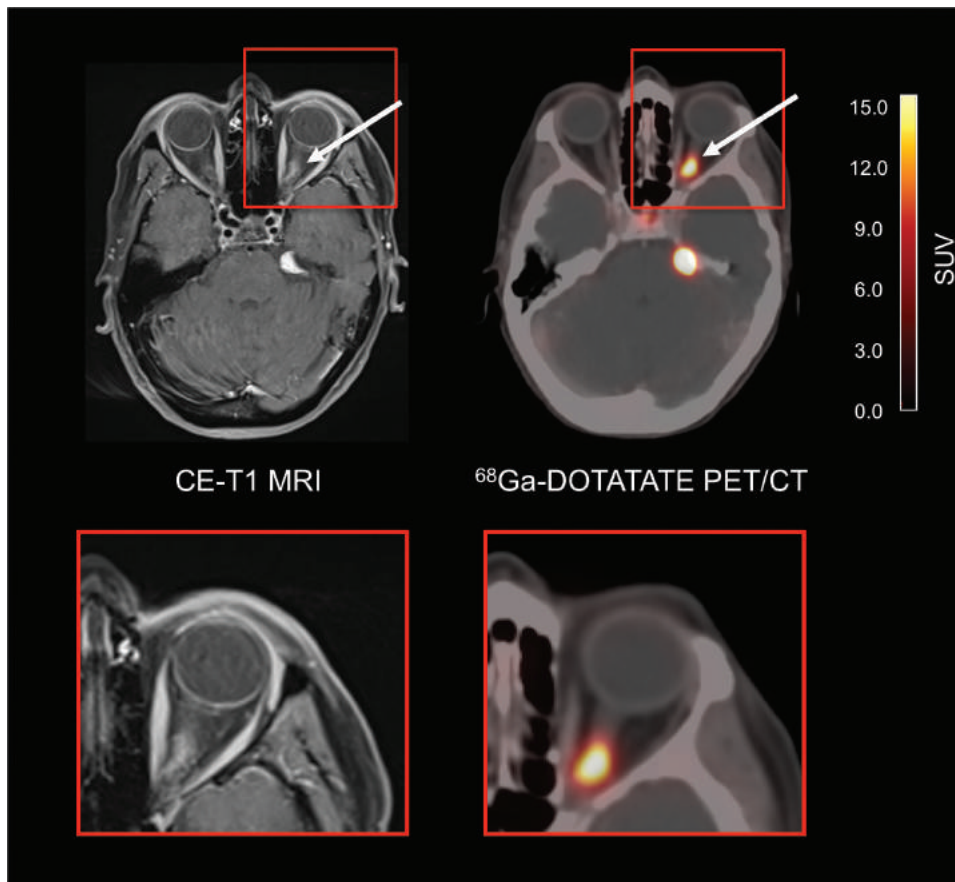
A 43-year-old female patient with a history of a meningioma of the left optical sheath treated with surgery and radiotherapy 8 years ago. At follow-up, ^{68}Ga -DOTATATE PET/CT reveals multiple meningioma lesions, including meningioma recurrence at the optical sheath (arrows).
